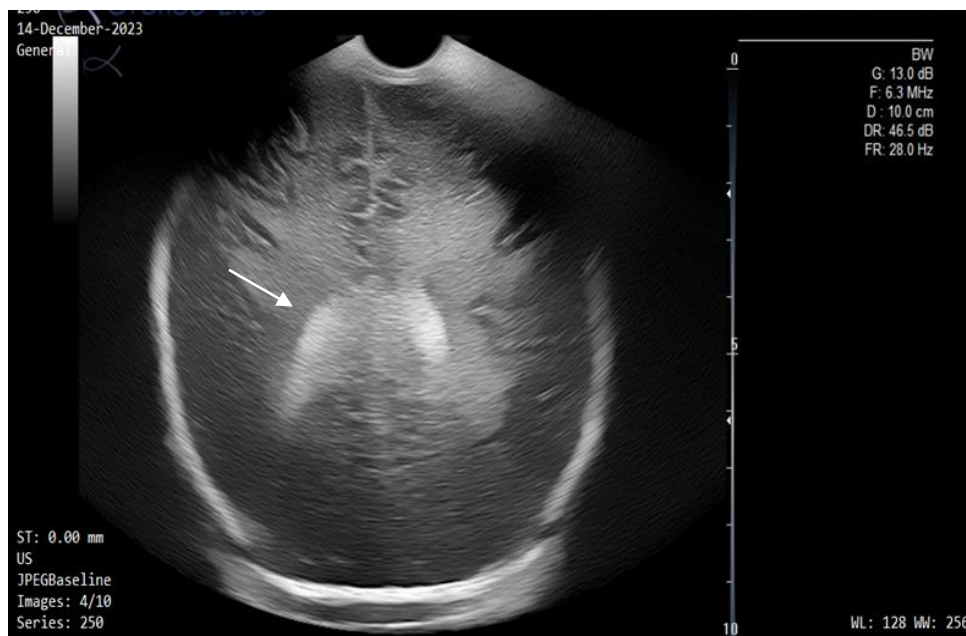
Coronal plane: male neonate, 41 weeks gestation, 3110 grams, CS delivery due to NRFS, moderate HIE. Day one cranial ultrasound shows periventricular echogenicity. Neonate succumbed before day seven.
